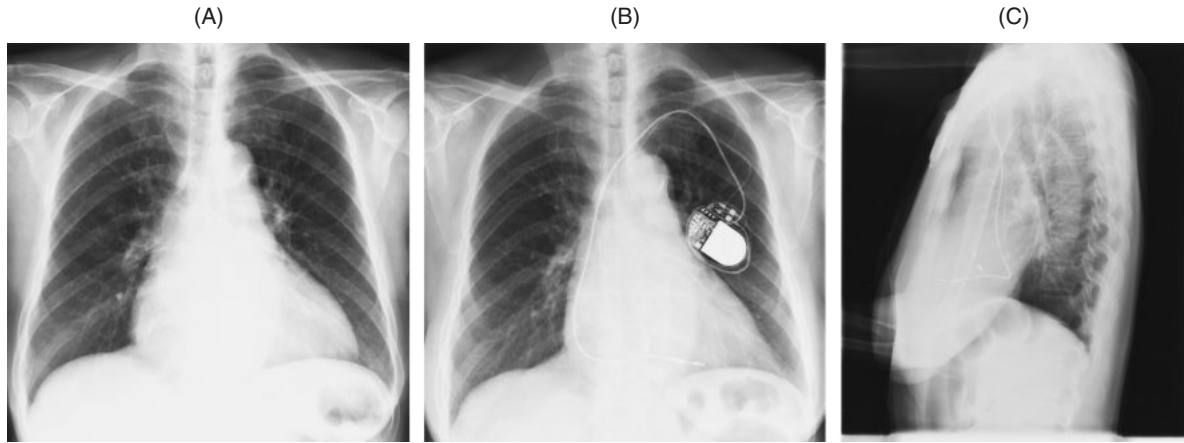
Radiographic images showing reduction in heart size, before (A) and after sustained DHBP in about one month (B), (C). The CTR decreased from 62% to 56% in about one month.
